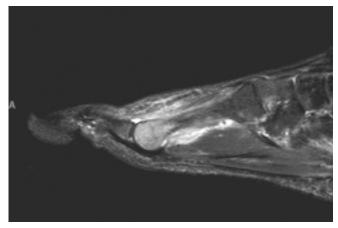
Magnetic resonance imaging, T-2 weighted sagittal view. Note the increased signal intensity at the second metatarsal head.
